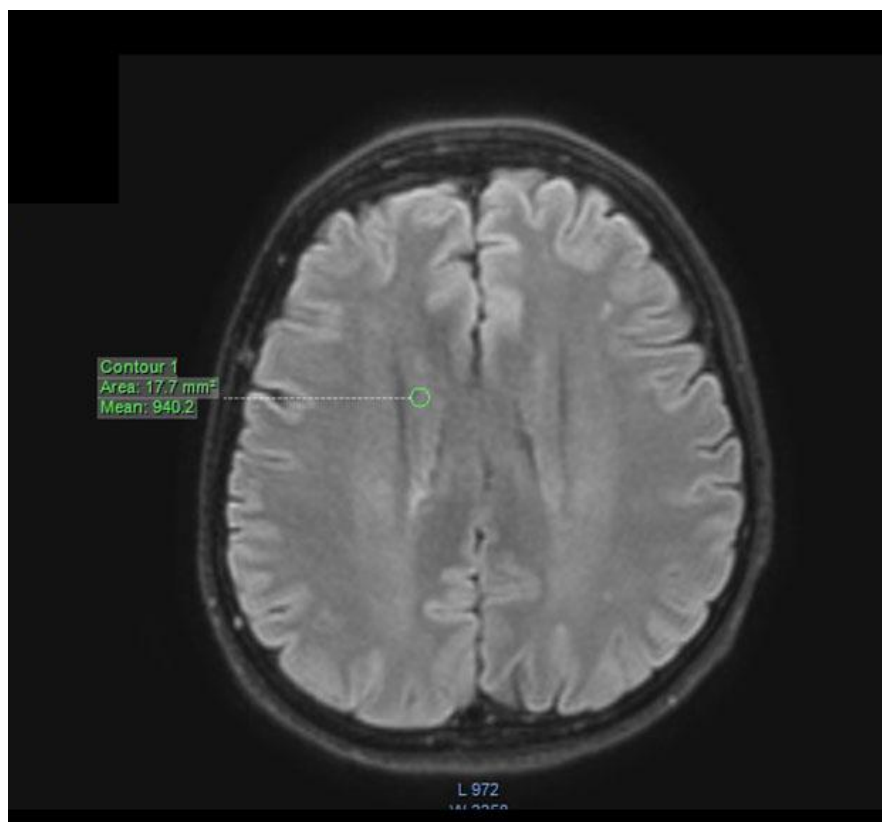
An example of circular single-ROI placement on white matter region. This ROI were identified on FLAIR image.
